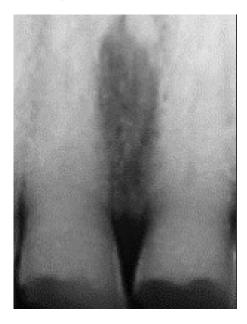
and 62B. Periapical radiographs demonstrating erosion of anterior (A) and posterior (B) teeth.
